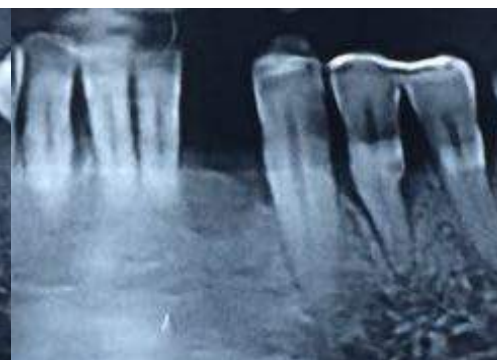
The radiographic evaluation 4 months post first surgery
